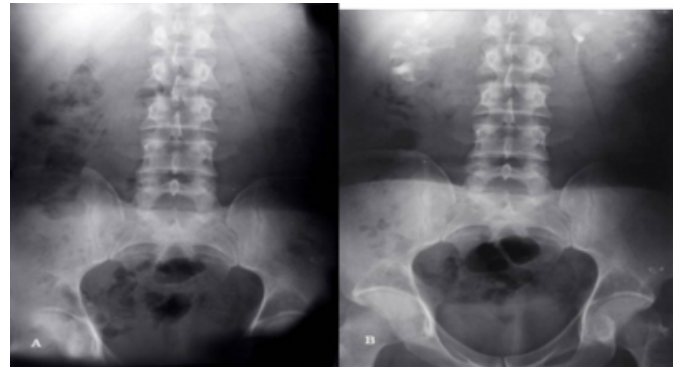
AB: Plain abdominal x-ray and IVU are showing proximal ureteral stones and grade IV hydronephrosis on the right-sided urinary system. C: Plain abdominal x-ray is demonstrating upward migrated DJ stent on the same side. D: Post-operative first day plain abdominal x-ray is showing successful fragmentation (stone-street).
